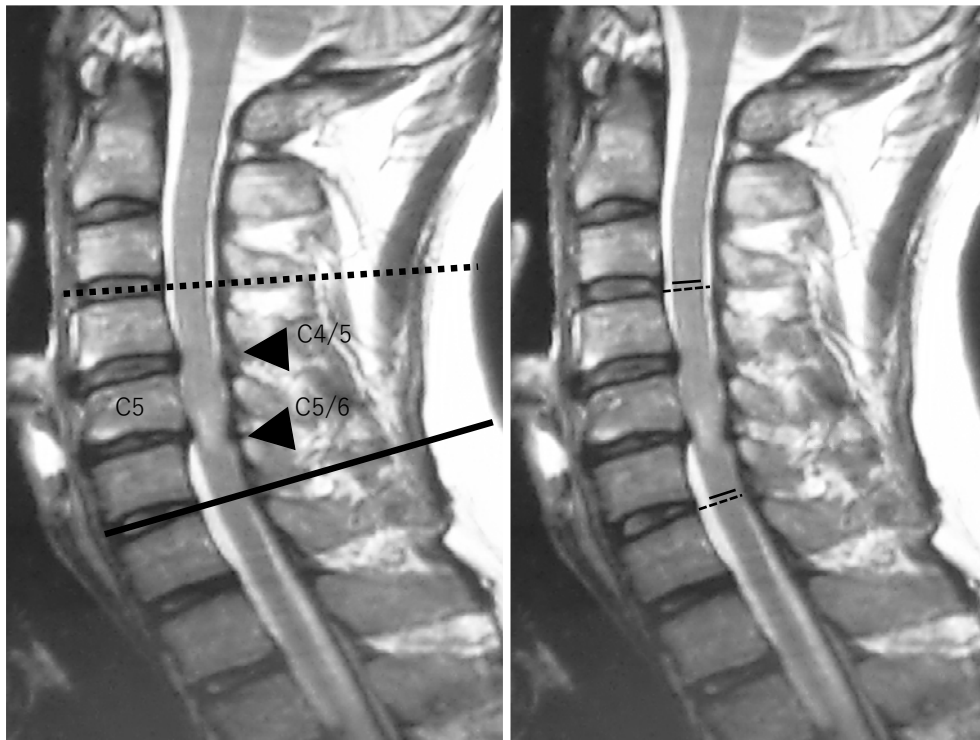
Definition of the adjacent segment and measurement of the anterior–posterior diameter. The left picture shows the MRI of a patient who underwent a single laminectomy of C5 for two-level stenosis at C4/5 and C5/6 (arrowhead). Here, the upper adjacent segment is C3/4 (dotted line), and the lower adjacent segment is C6/7 (solid line). The right picture shows the measurement of the anterior–posterior diameter of the spinal cord (solid line) and the anterior–posterior diameter of the dural tube (dotted line) at the adjacent segment. The measurements were taken orthogonal to the spinal cord and at the site with the least residual space for the spinal cord at the disk level.
